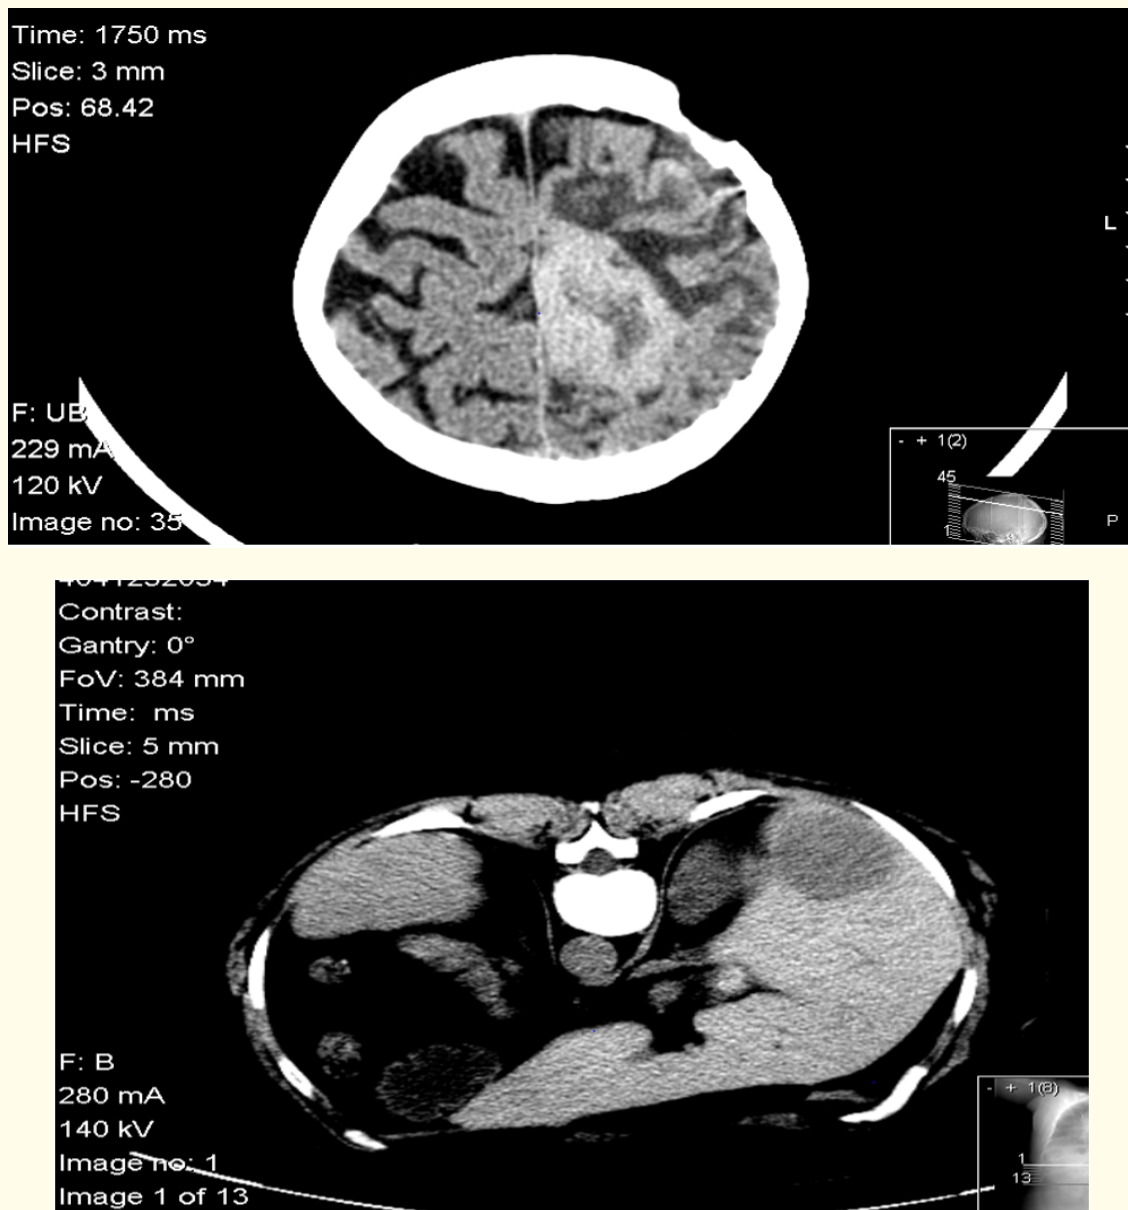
MRI shows residual tumor tissue at the left parietal area in parasagittal location surrounded by grade II perifocal edema.
